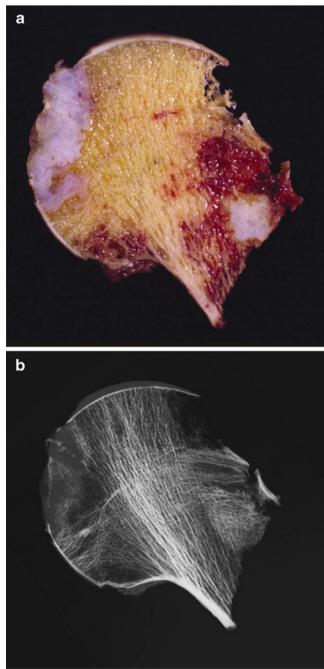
a Coronal section and b corresponding radiograph of the femoral head and neck demonstrating foci of cartilaginous tumor in the fovea and the posterior neck, which are infiltrating and destroying the bone. Note the irregular invasive borders of the tumor
